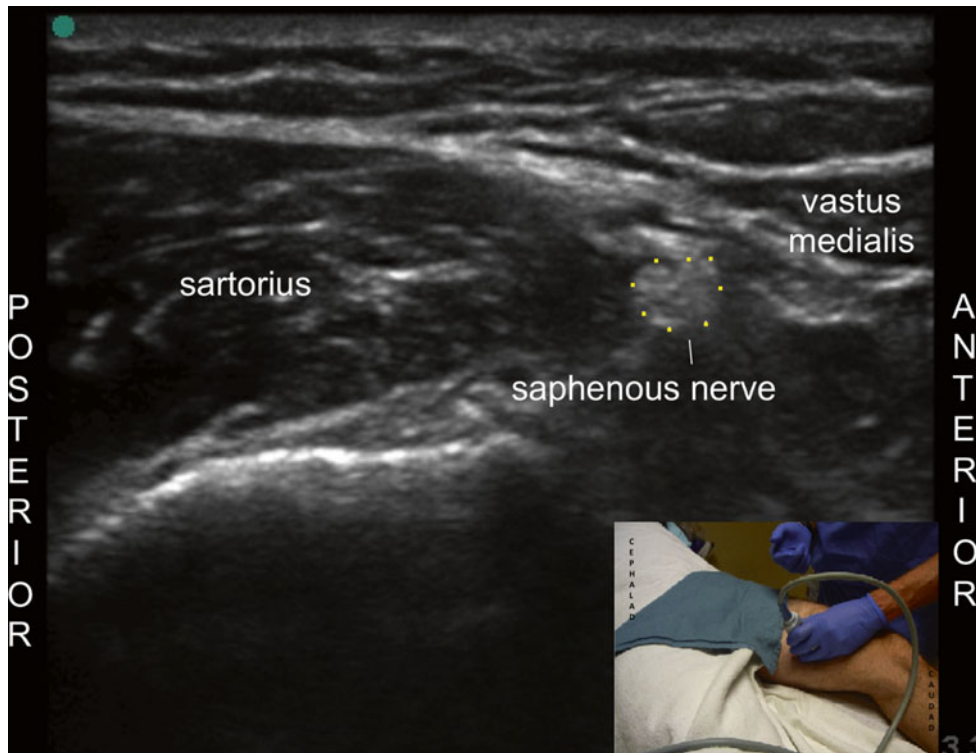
Ultrasound identification and injection of the proximal saphenous nerve in the adductor canal (Image courtesy of Thiago Nouer Frederico, MD)
